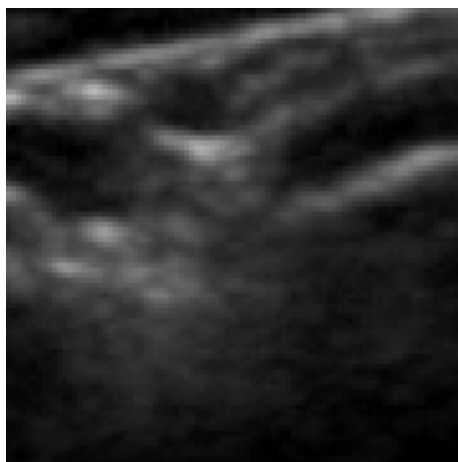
A sample ultrasound label patch where a part of the IJV is inside the patch.
